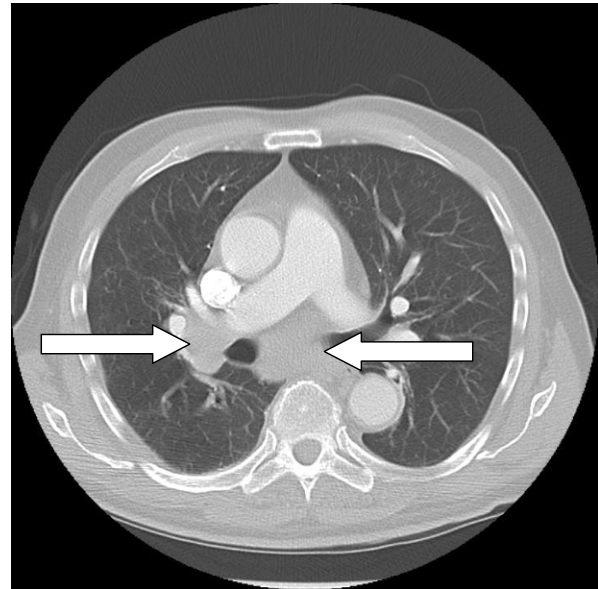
Horizontal CT scan of the chest. A moderate mediastinal lymphadenopathy (arrows) is present without a visible primary site of lung cancer.
